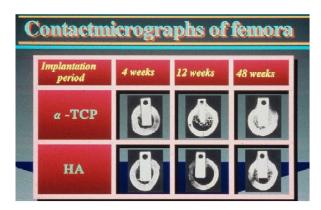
Soft X-ray appearance of α - TCP and HA coating sample
